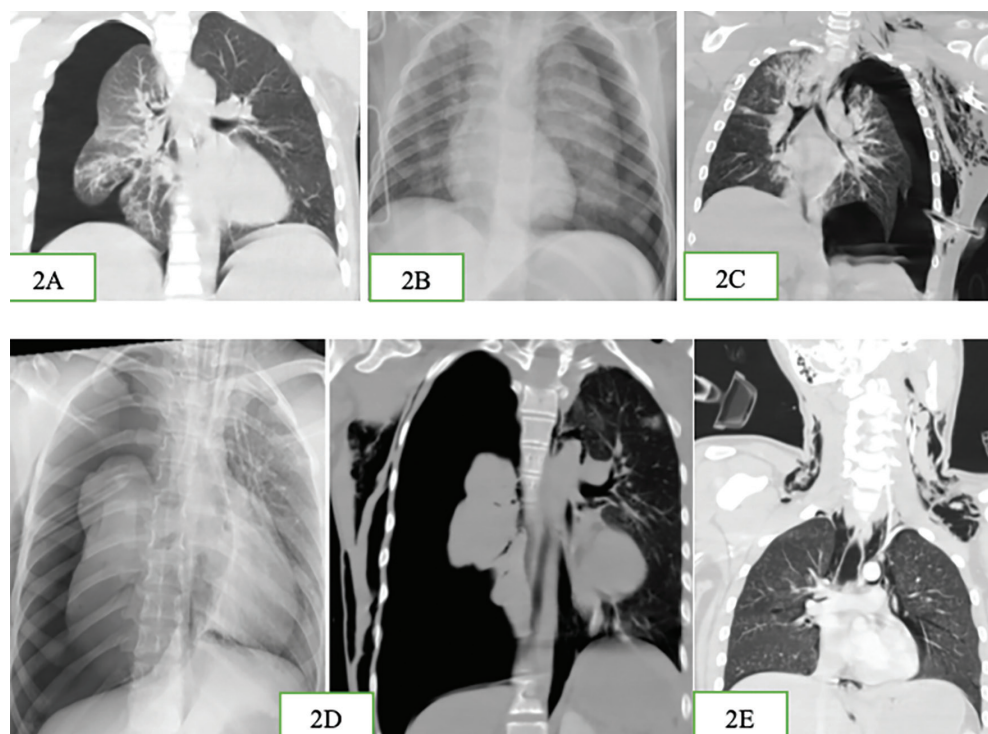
Radiological images of cases. A) A right pneumothorax is seen on computed tomography of Case 1. B) Left hemopneumothorax is seen on the PA radiograph of Case 2. C) Thoracic computed tomography image of Case 3 shows pneumomediastinum, pneumothorax, subcutaneous emphysema, and collapsed lung tissue. The pediatric surgery team performed surgical repair on the patient's left lung and chest wall. D) Persistent massive pneumothorax and collapsed lung tissue are seen on PA chest radiography and thoracic computed tomography performed after tube thoracostomy in Case 4. When the patient underwent a thoracotomy performed by the pediatric surgery team, complete separation of the right main bronchus was observed, necessitating a total resection of the right lung. E) Thoracic computed tomography shows pneumomediastinum and subcutaneous emphysema. The patient was followed for a displaced occipital fracture, subarachnoid hemorrhage, parenchymal hemorrhage, pulmonary contusion, pneumothorax, pneumomediastinum, and subcutaneous emphysema sustained in a fall that followed a cranial gunshot wound. The patient underwent bilateral tube thoracostomy and bronchoscopy for persistent pneumomediastinum. The tracheobronchial structures were normal. Pulmonary findings resolved during follow-up. The patient was extubated 2 weeks later
